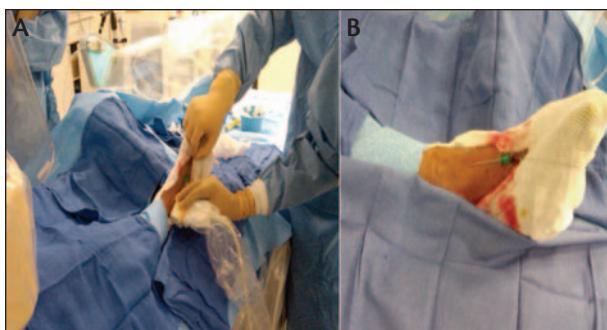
Dorsalis pedis artery access using ultrasound guidance (A) and a Micropuncture® needle (B).
